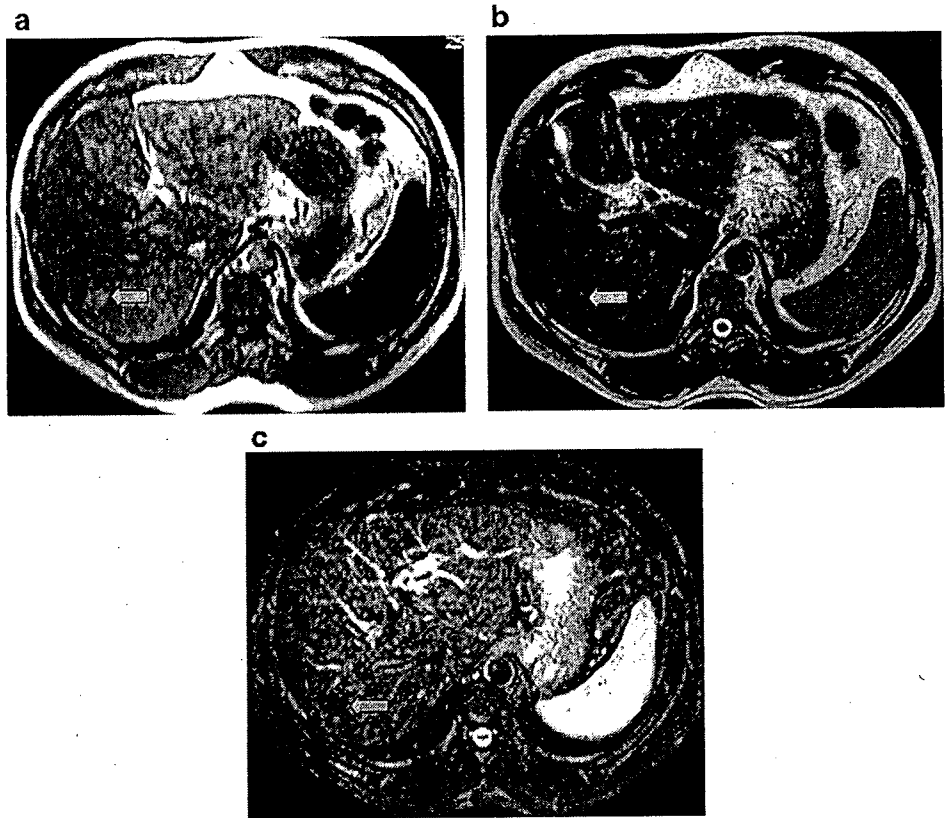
MR findings for a fat-containing, early HCC in a patient with cirrhosis due to chronic hepatitis B. The nodule (*arrow*) appears hyperintense on T1-weighted image (a), remains slightly hyperintense on T2-weighted image (b) and becomes hypointense on fat-saturated (SPIR sequence) image (c)
